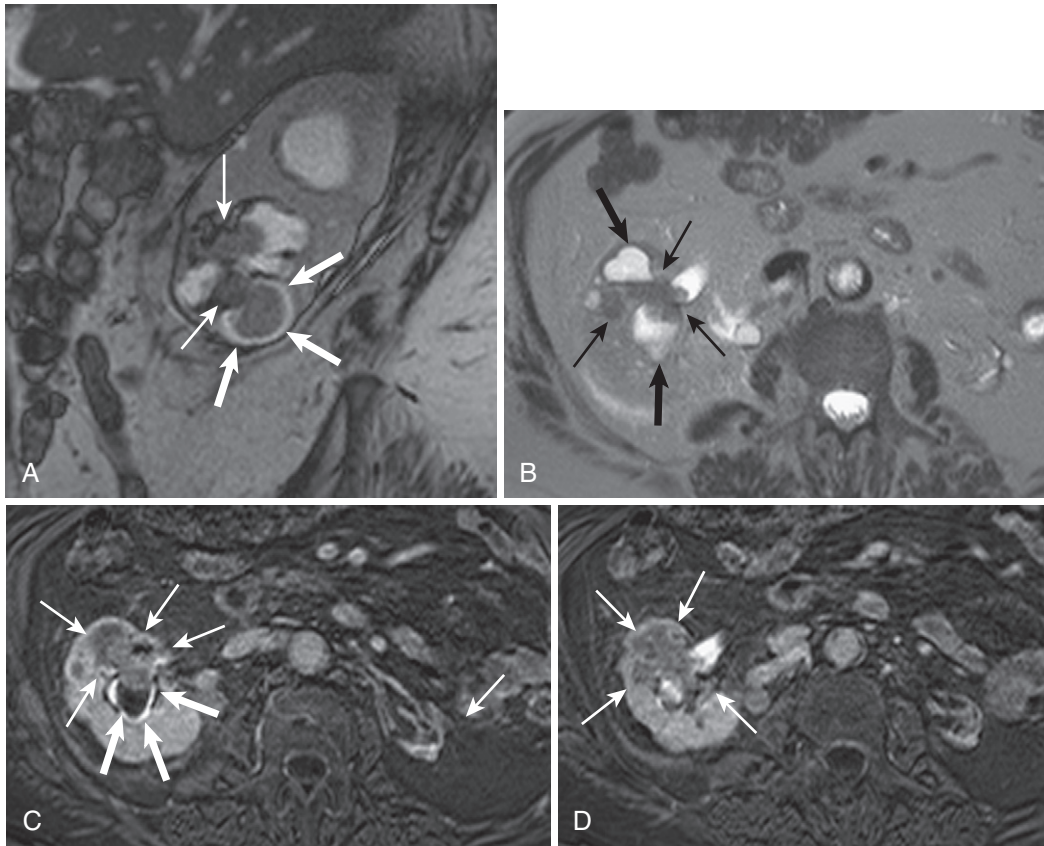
Calyceal findings of TCC. A, The sagittal steady-state image reveals an ill-defined mass (*thin arrows*) surrounded by dilated calyces; a thin rim of fluid hyperintensity (*thick arrows*) encircles tumor protruding into a lower polar calyx. B, The axial T2-weighted image portrays the infiltrative intrarenal mass (*thin arrows*) inducing oncocalyces (*thick arrows*). C and D, The postcontrast pyelographic phase images better depict the infiltrative nature of the hypovascular mass (*thin arrows*), encircled by a thin rim of excreted contrast (*thick arrows* in C) in a dilated calyx, which also contains hypointense debris or hemorrhage.
